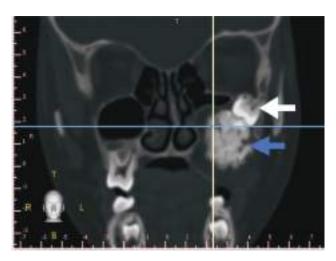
Coronal cut CT scan showing impacted permanent molar and large amorphous opacity surrounded by a defined radiolucency.
